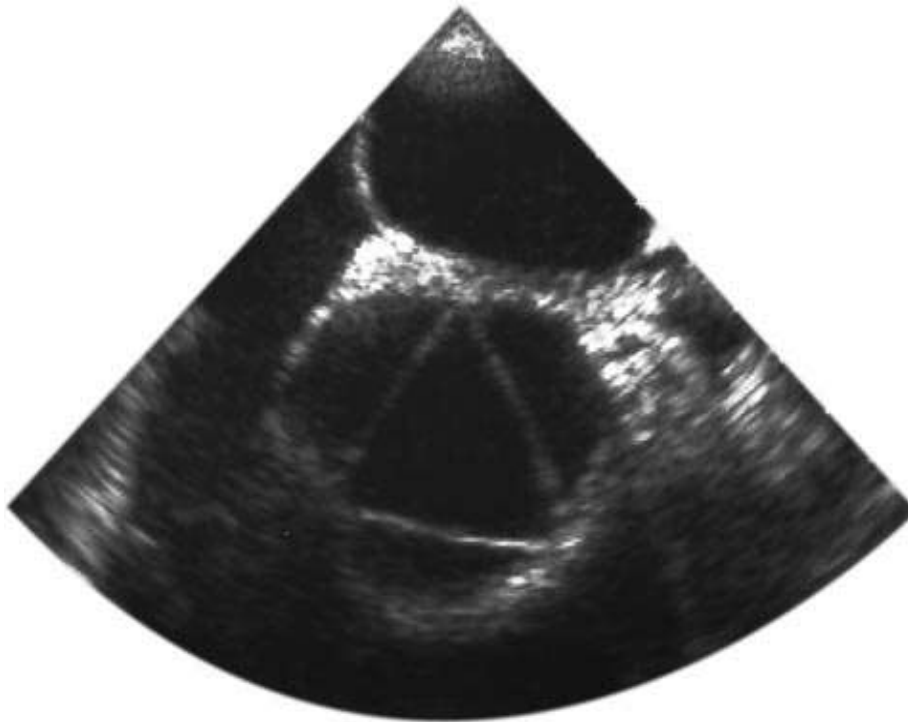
Transesophageal echocardiography across the aortic valve demonstrating the triangular shape of the open leaflets. Short-axis, basal view, 40 degree angle (*Magdi H. Yacoub et al. [4]*)
